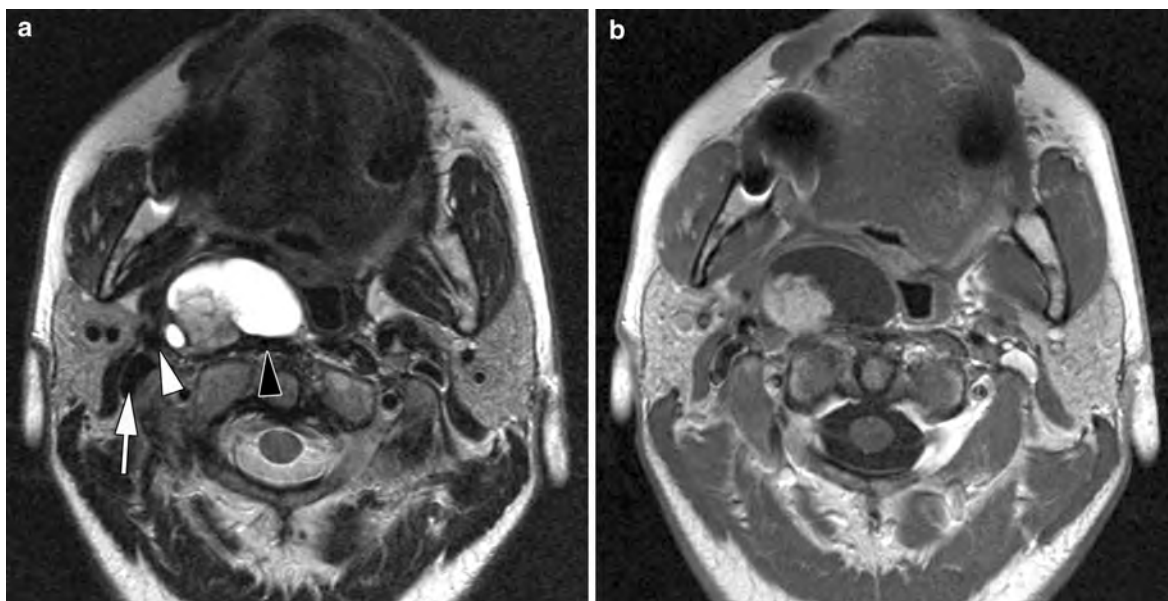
Asymptomatic, 42-year-old female patient, with coincidentally discovered peritonsillar swelling on right side. Axial T2-weighted (a) and gadolinium-enhanced T1-weighted (b) spin echo images show largely cystic lesion, filling the prestyloid compartment of the PPS. The mass is centered between the prevertebral muscle (*black arrowhead*) and internal carotid artery (*white arrowhead*), a typical localisation
